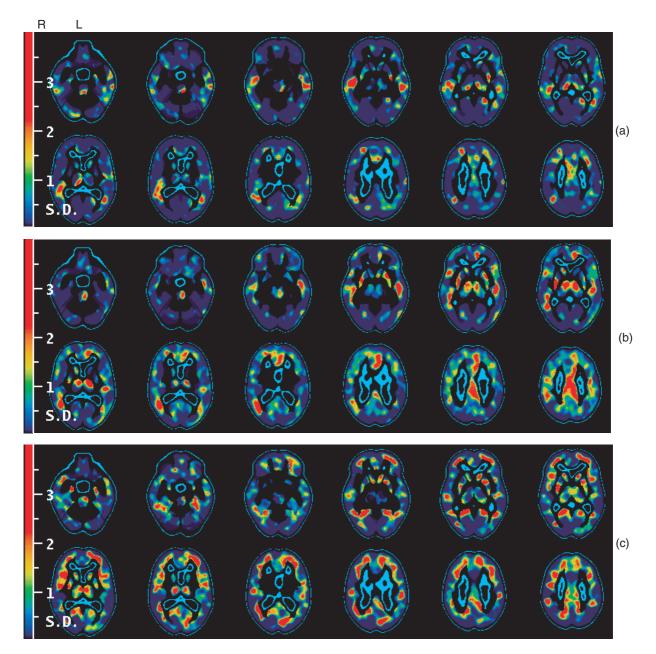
Parametric images of rCBF-SPECT studies of patient I (a), II (b) and III (c). Axial slices show regional cerebral blood flow (rCBF)-reduction as pixelwise colorcoded *z*-scores (number of standard deviations from mean) resulting from an automated comparison of the individual SPECT studies with a normal template (software BRASS). Areas of significantly reduced rCBF are colored in red.
